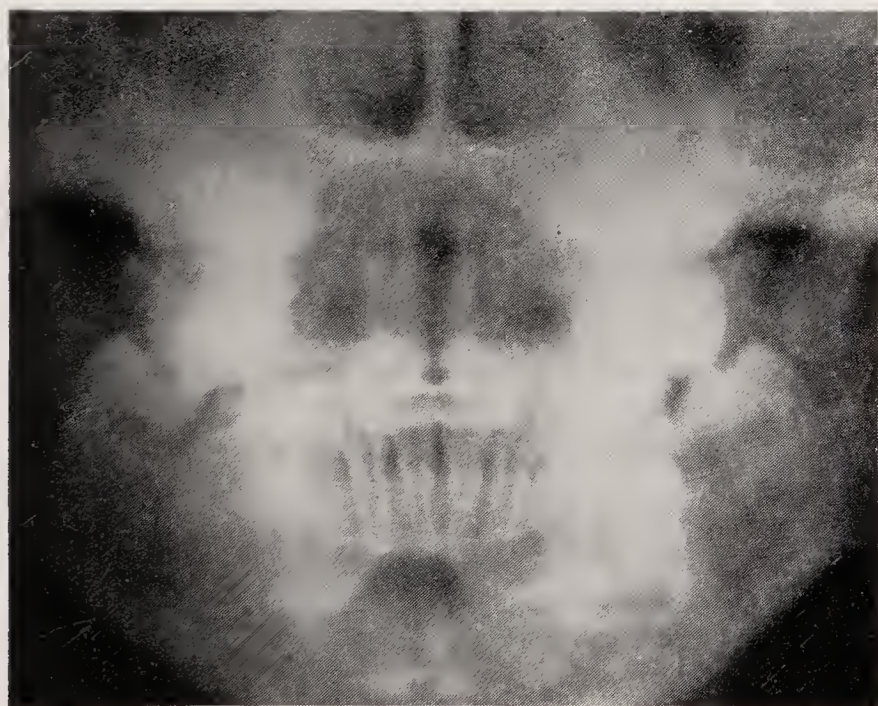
Anteroposterior X-ray with barium paste along the lip line.
